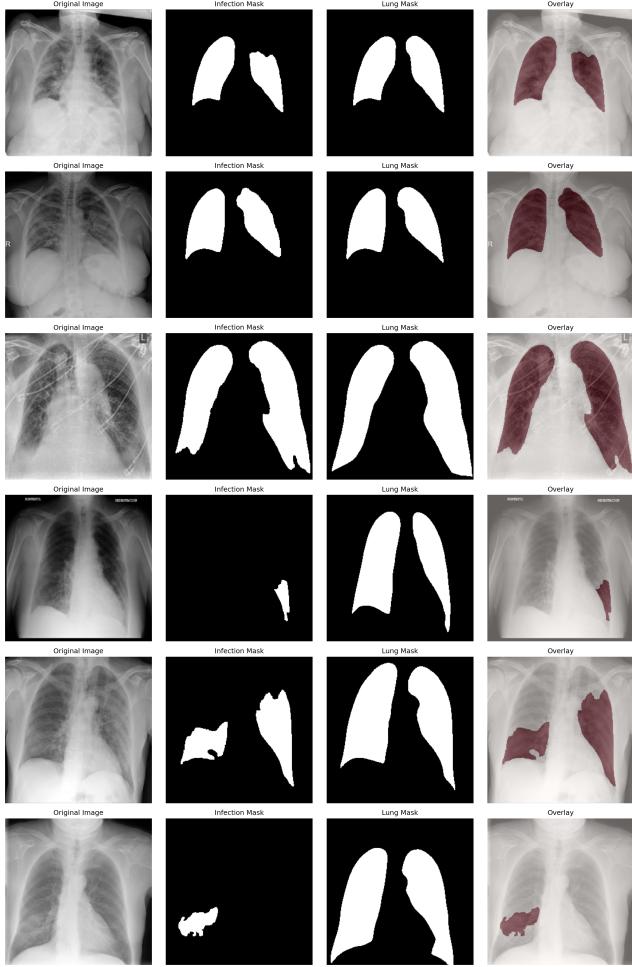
Example chest X-ray images with corresponding lung and infection masks
